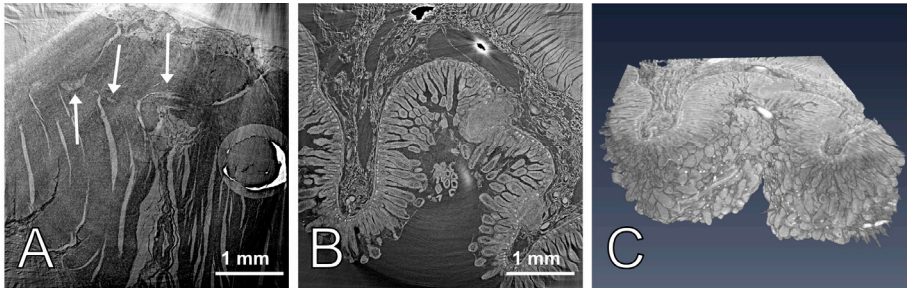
SR μ CT of full-size biopsy blocks as future line of work.
